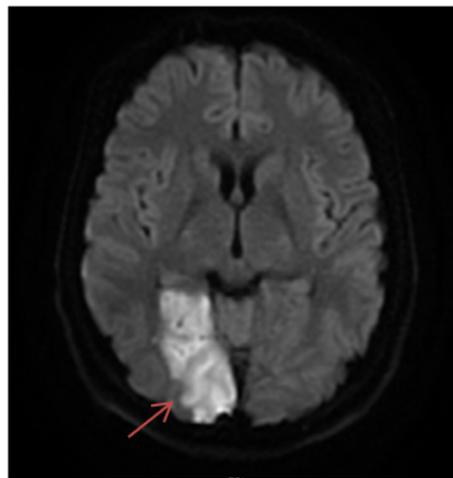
Diffusion-weighted magnetic resonance sequence of MRI brain, axial view, showed high signal intensity in the right occipital cortex.
